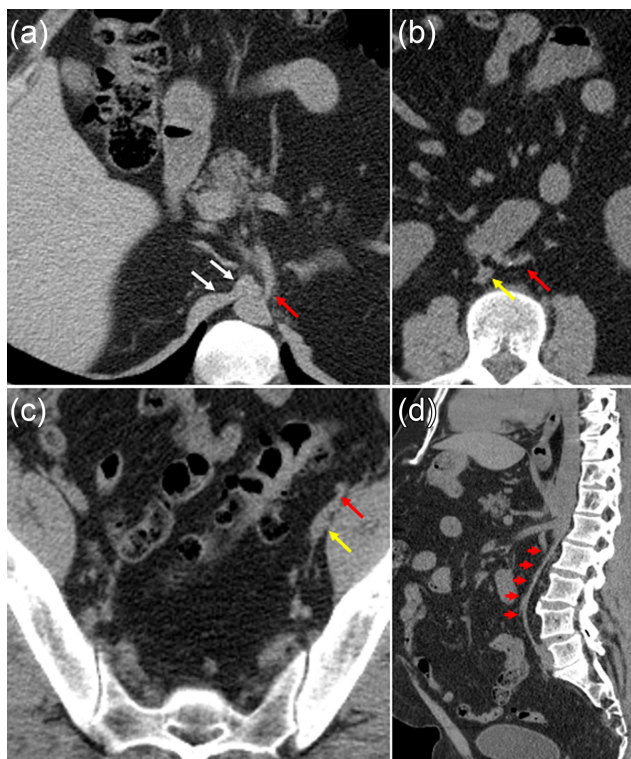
Initial computed tomography of the abdomen and pelvis without contrast (A-D) was performed for the identification of hernia. The axial image at the level of the diaphragm (A) shows narrowed origin of the celiac trunk (red arrow) by the contraction of the diaphragmatic crura (white arrows). Axial images at the level of the infra-renal aorta (B) and through the mid-pelvis (C) show marked compression of the abdominal aorta (red arrow in "b") and IVC (yellow arrow in "b") as well as the left external iliac artery (red arrow in "c") and vein (yellow arrow in "c"). Sagittal multi-planar reconstruction (MPR) image (D) demonstrates marked severe narrowing of the abdominal aorta (arrows).
